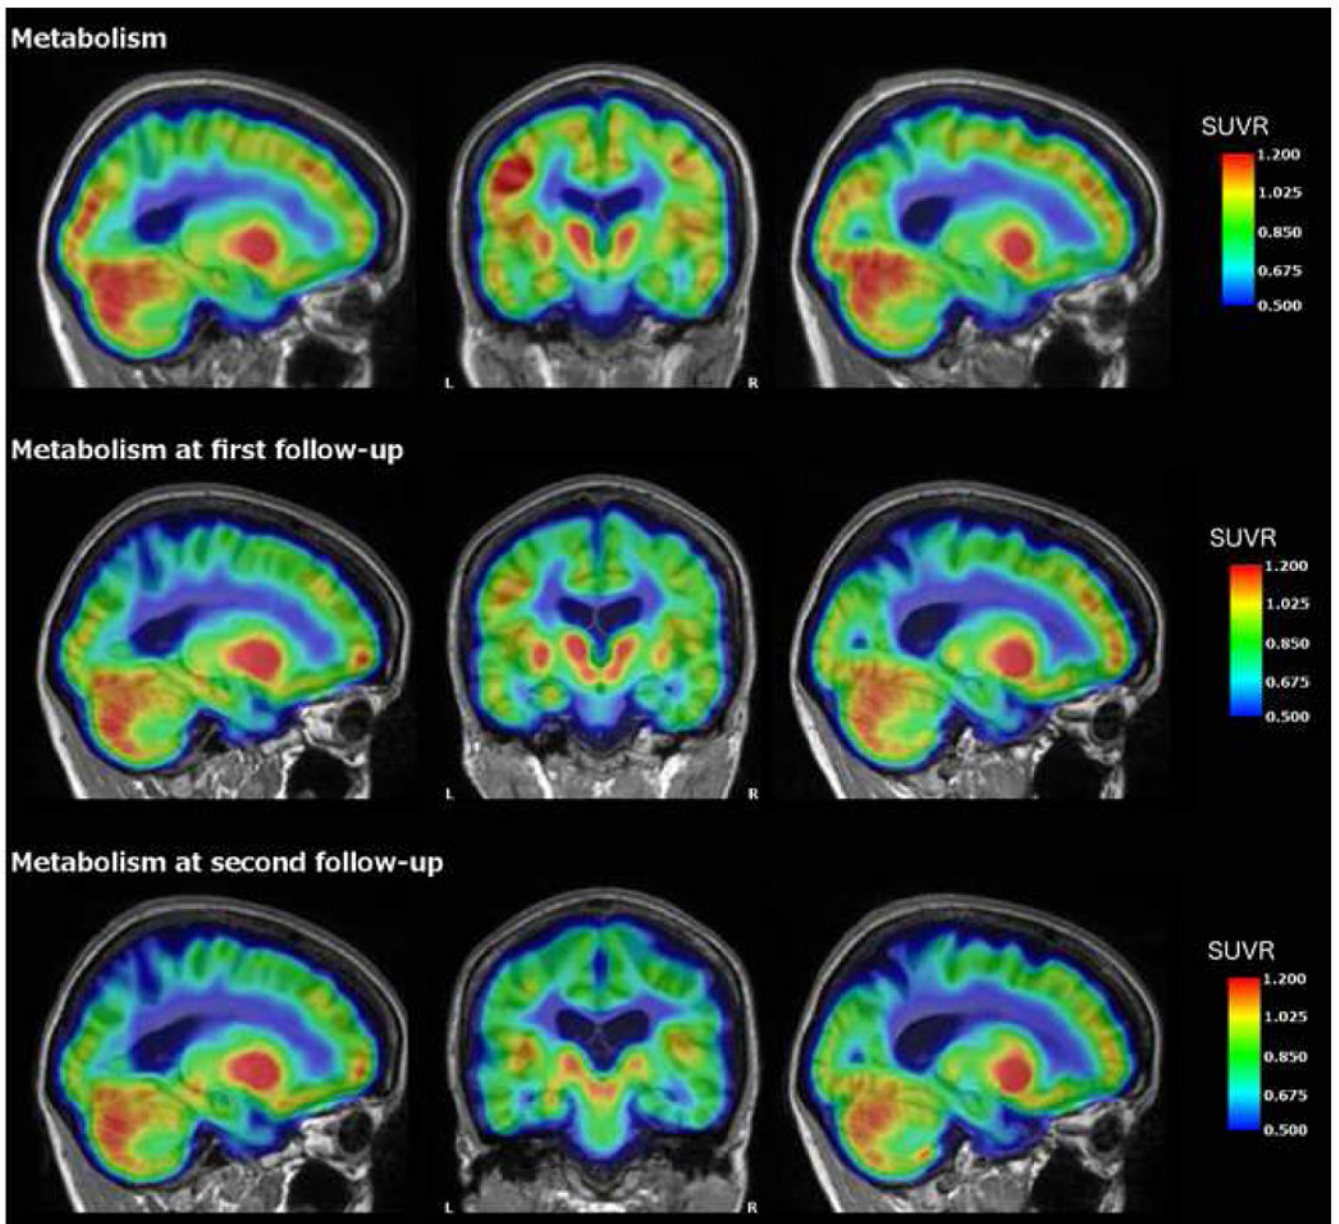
FDG-PET for Case 1 depicting metabolism across the cortex at baseline and annual follow-up one and two years later. There is progressive hypometabolism in the precuneus, which is typical for ADAD mutation carriers as the disease progresses. Of particular note is elevated metabolism in the left hippocampus relative to the right throughout the course. Values represent SUVRs relative to cerebellar gray.
